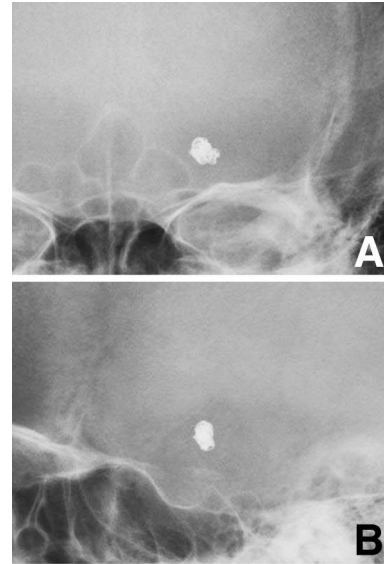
Follow-up radiographs, frontal view (A) and lateral view (B), 3 months after endovascular treatment revealing obvious reduction in size and compaction of the coil mass.
